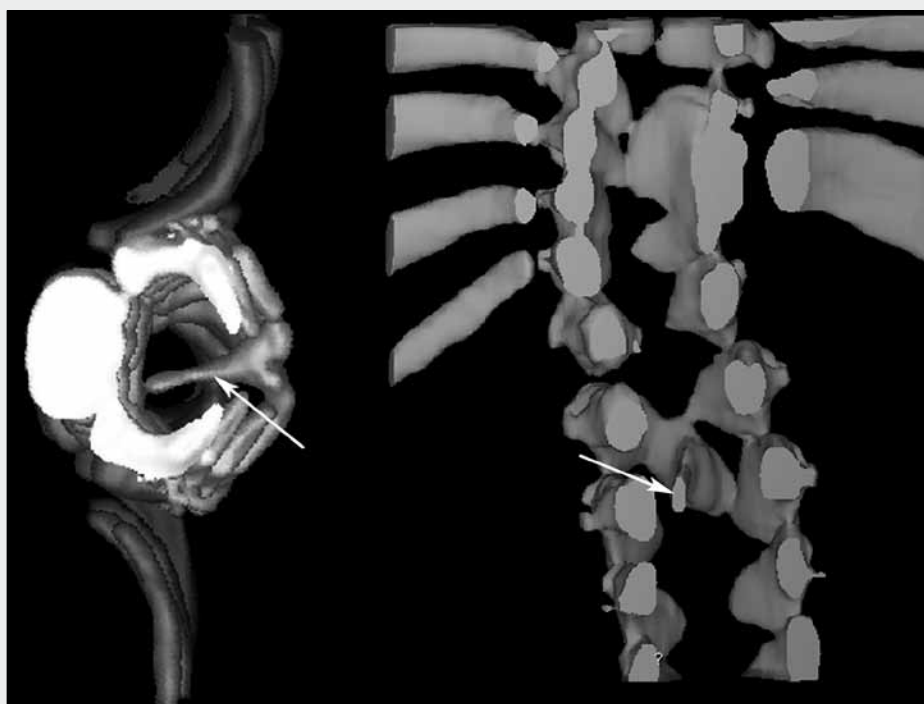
CT 3D showing ossified septum at L3 level
